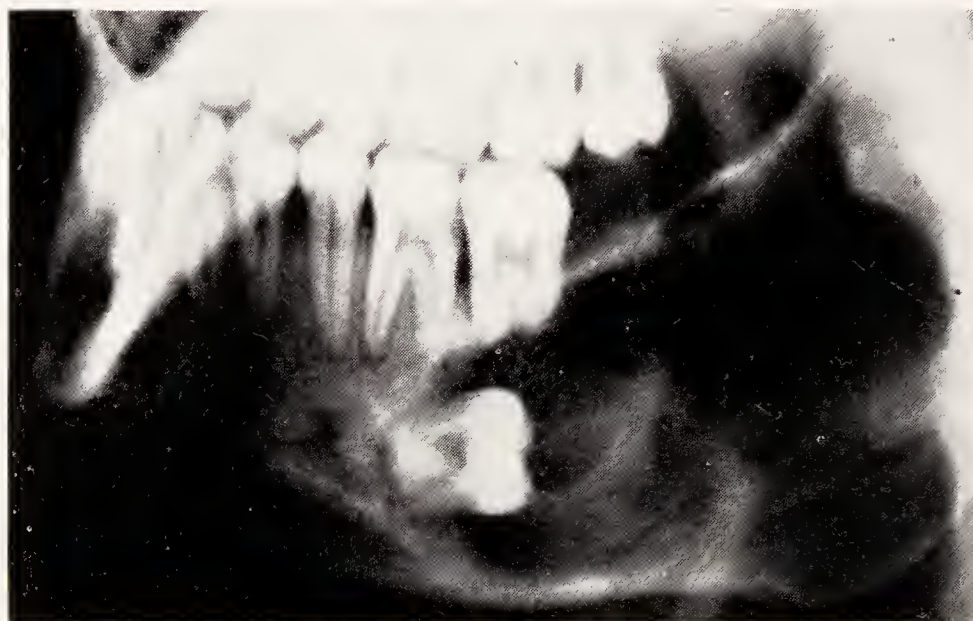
Radiograph of a large dentigerous cyst involving angle and ramus of the mandible. The cyst developed from the lower third molar which is displaced below the roots of the first and second molar.
